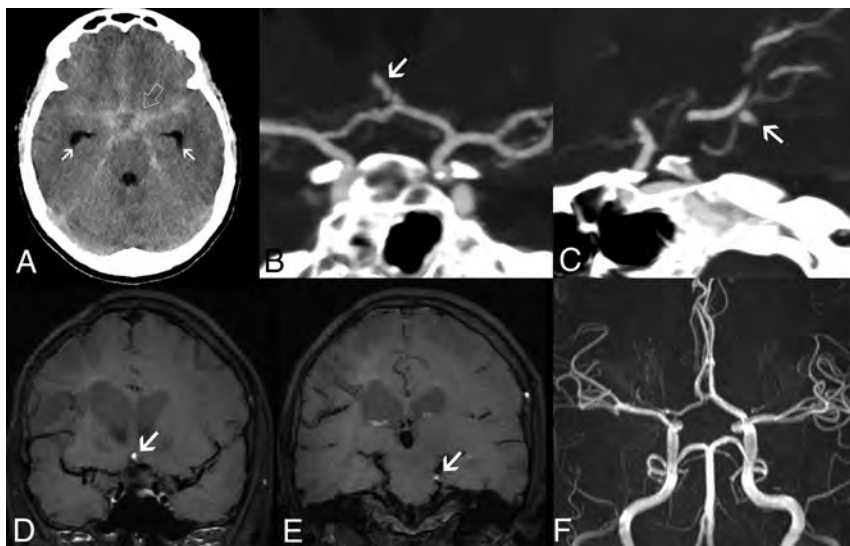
Intracranial aneurysms in adenosine deaminase deficiency. Axial unenhanced head CT scan in patient 5 at 16.4 years of age (A) demonstrates a diffuse subarachnoid acute hemorrhage (SAH) (open arrow) symmetrically distributed in the basal cisterns, horizontal segments of the Sylvian fissures, and anterior interhemispheric fissure, with mild enlargement of the temporal horns in keeping with incipient hydrocephalus (arrows). CTA images (B and C) reveal the presence of small-sized intracranial aneurysms of an anterior communicating artery branch (arrow) and the left superior cerebellar artery (arrow). Note that these 2 aneurysms have a peripheral location and arise in nonbranching sites. Follow-up brain MR imaging performed 23 days after the initial SAH episode, including coronal (D and E) black-blood T1WI, shows signs of intraaneurysmal thrombosis (arrows). TOF-MRA (F) does not depict flow-related signal within the aneurysmal sacs, in keeping with exclusion of the aneurysms from the circulation. These aneurysms remained excluded from circulation at 5-year follow-up.
